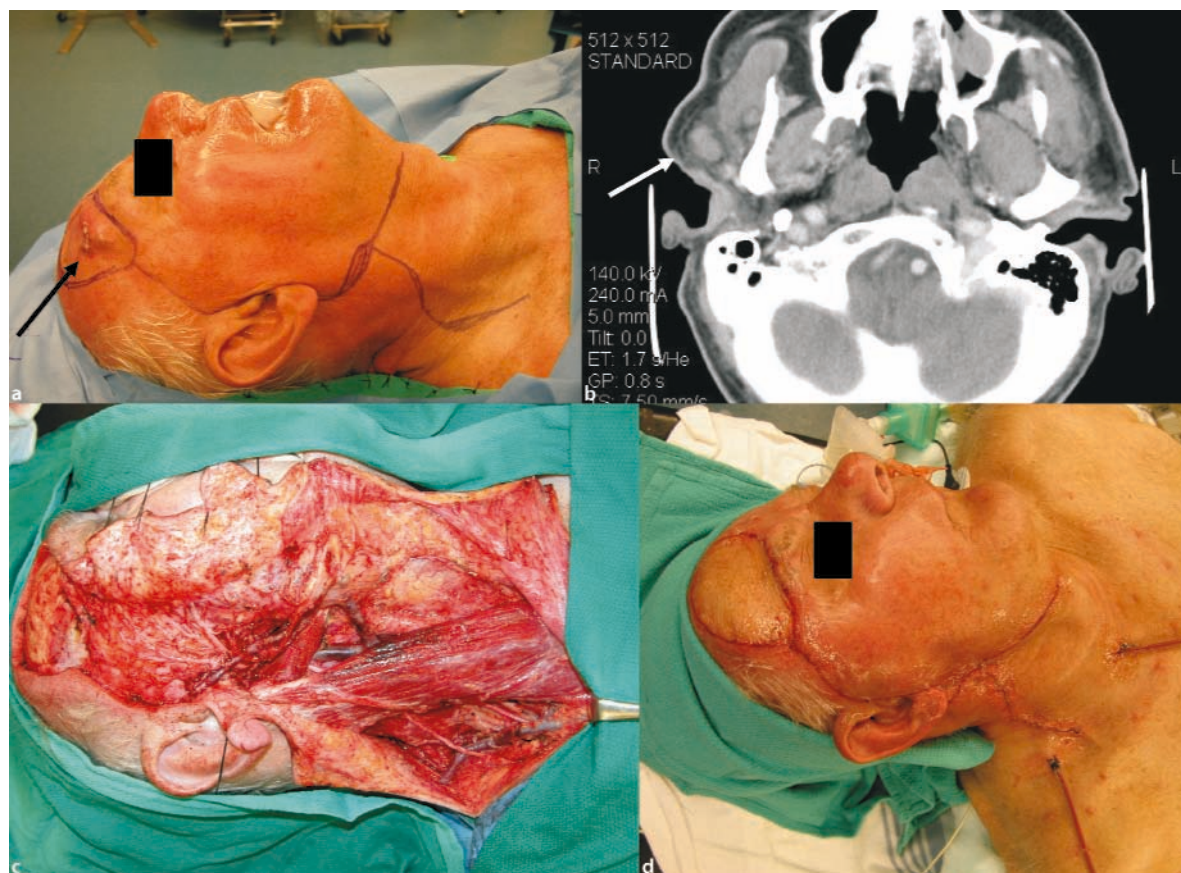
a Recurrent melanoma and intranasal metastases right forehead. b Nodal metastases right parotid (CT scan). c Wide local excision, subtotal parotidectomy with resection of subcutaneous lymphatics and functional neck dissection (cervical plexus sparing). d Reconstruction using anterolateral thigh free flap
